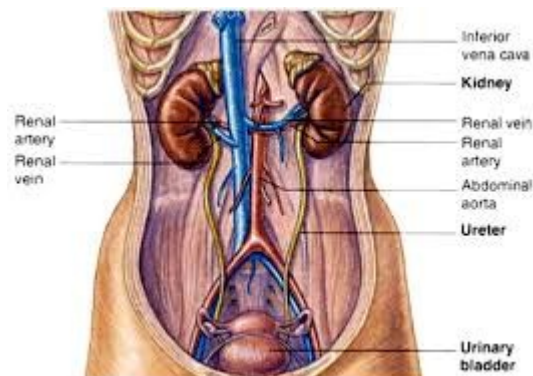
2: position of the Kidney and related organs (Radiographic .rsna.org.2009)
